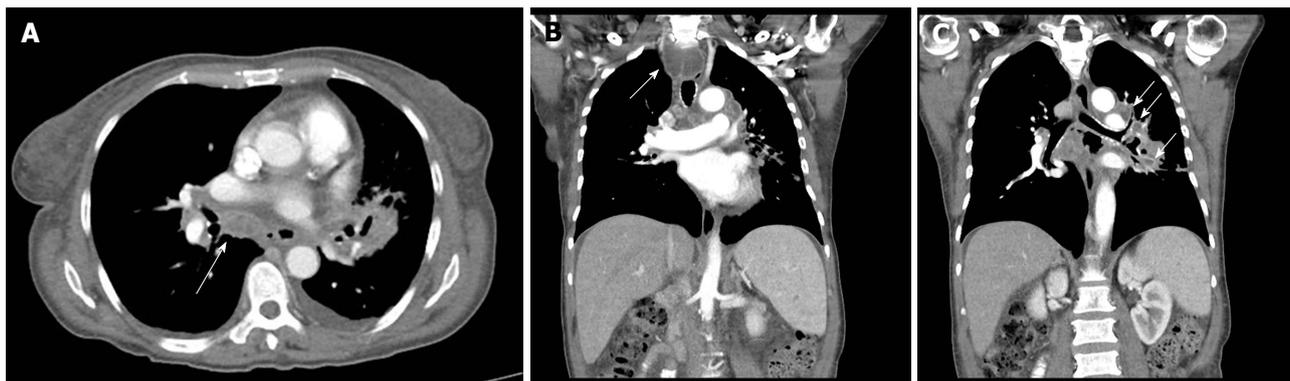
Chest computed tomography scan (scale W500:L50): Soft tissue window. Axial (A) and coronal (B, C) views: Superior mediastinal widening secondary to numerous lymphadenopathies (arrows) and a left hilar mass.
